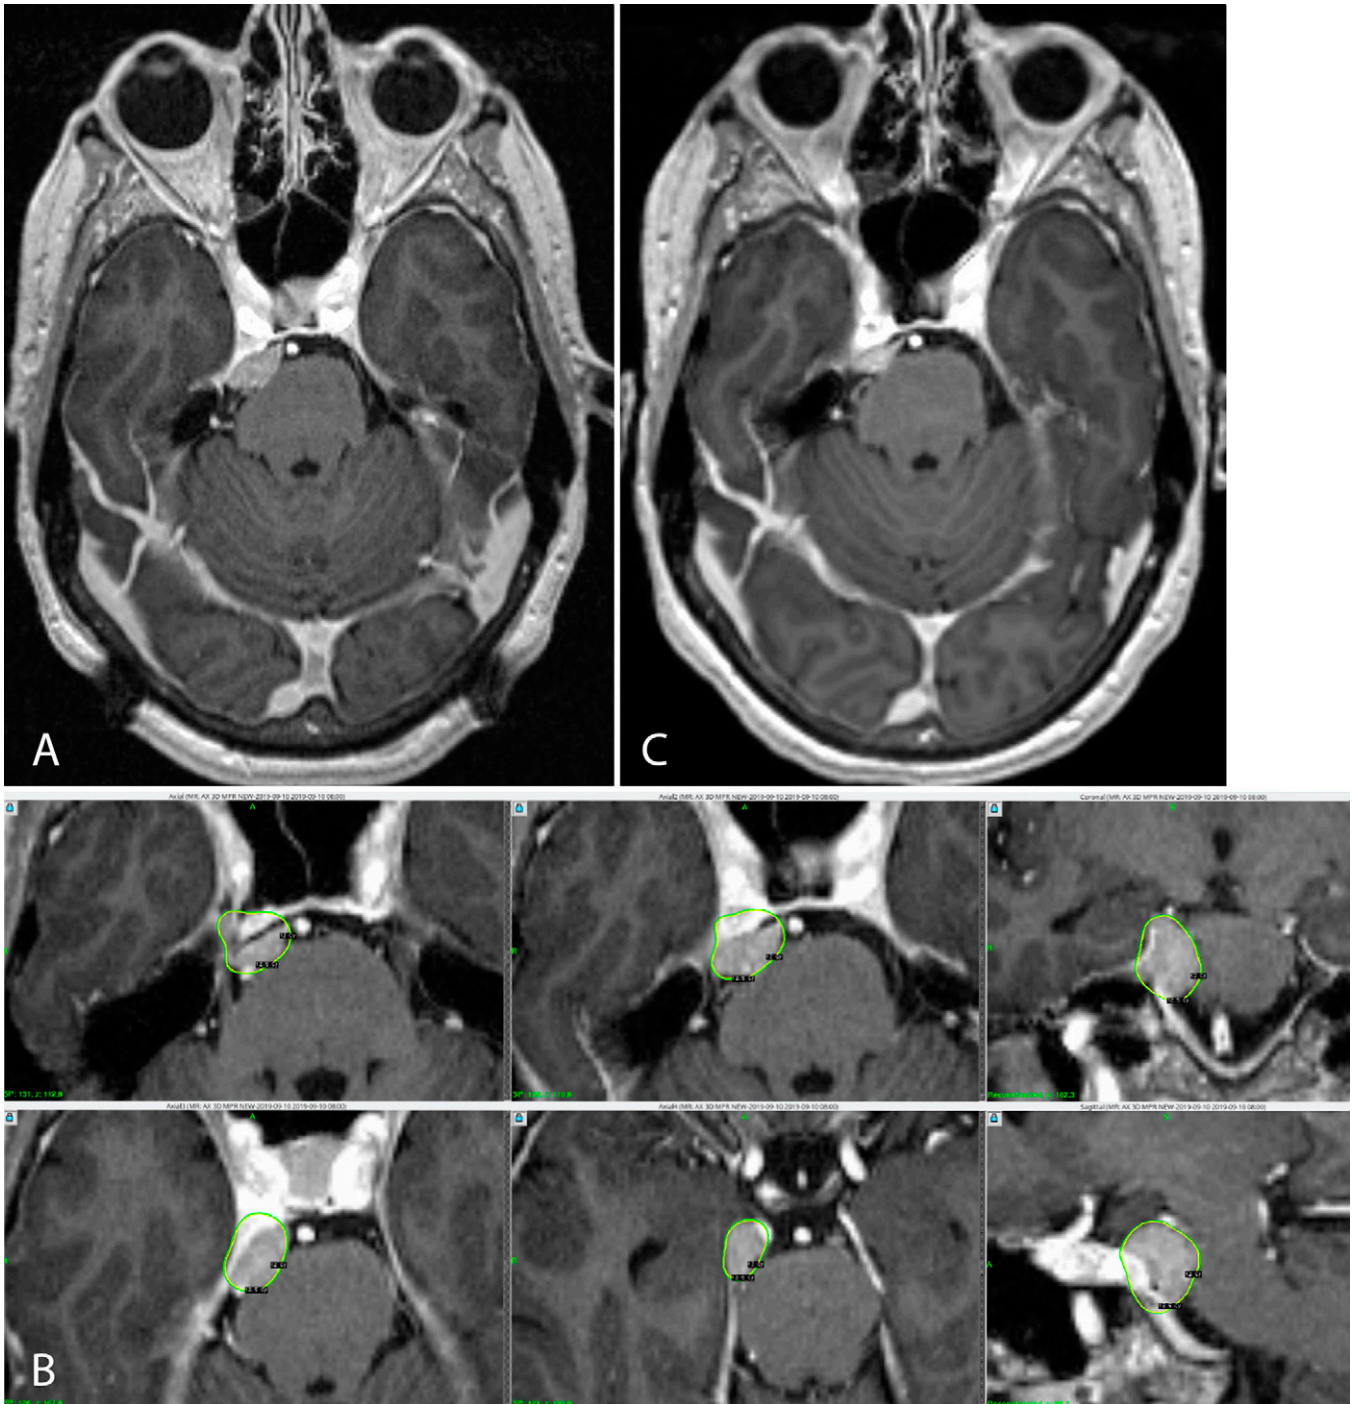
Case 10. Axial T1-weighted magnetic resonance imaging for GKS in a 61-year-old woman with a petroclival meningioma. Diplopia resolved within 1 month after surgery. Images with contrast before (A) and during radiosurgery using 12.5 Gy to the 50% isodose line (B). 20 months later, the tumor had regressed (C).
